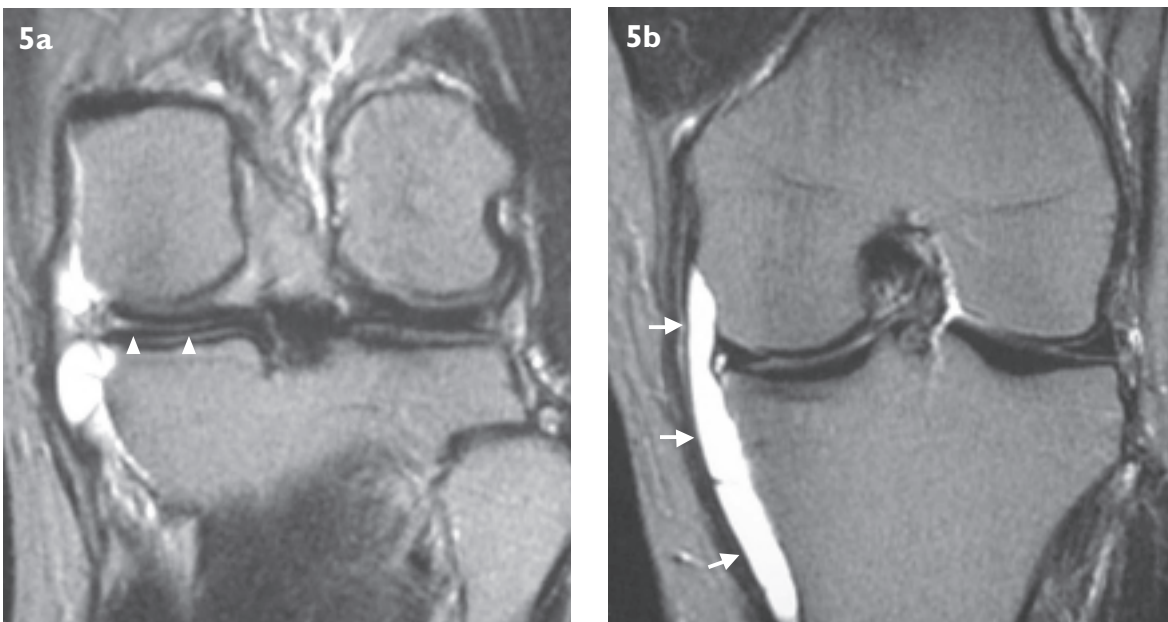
Medial meniscal cyst. Coronal fat suppressed T2-weighted MR image shows a (a) horizontal tear (arrowheads) of the posterior horn of the medial meniscus that communicates with a (b) large meniscal cyst (arrows).
